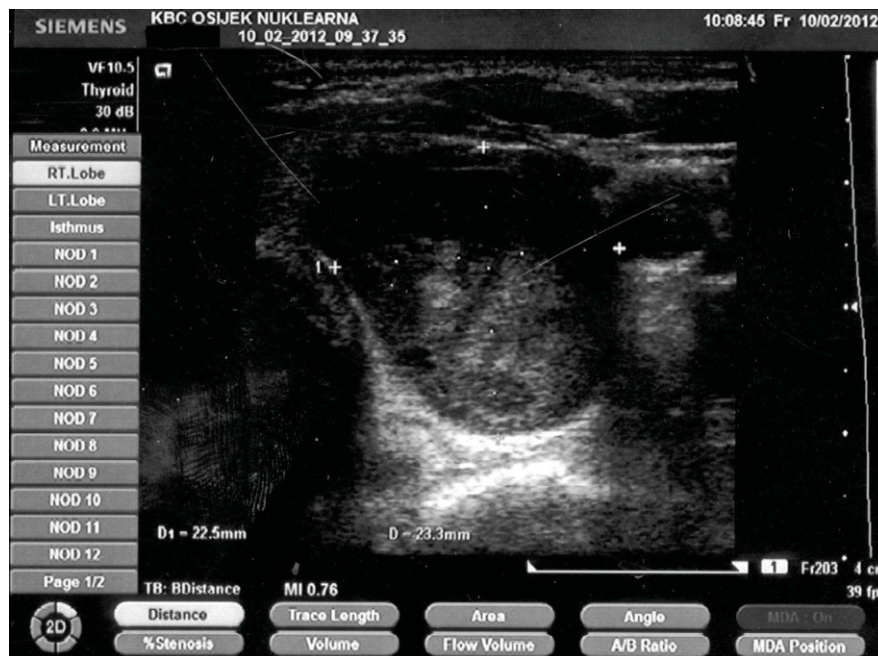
Thyroid ultrasound showing lobe enlargement and nodal changes.
